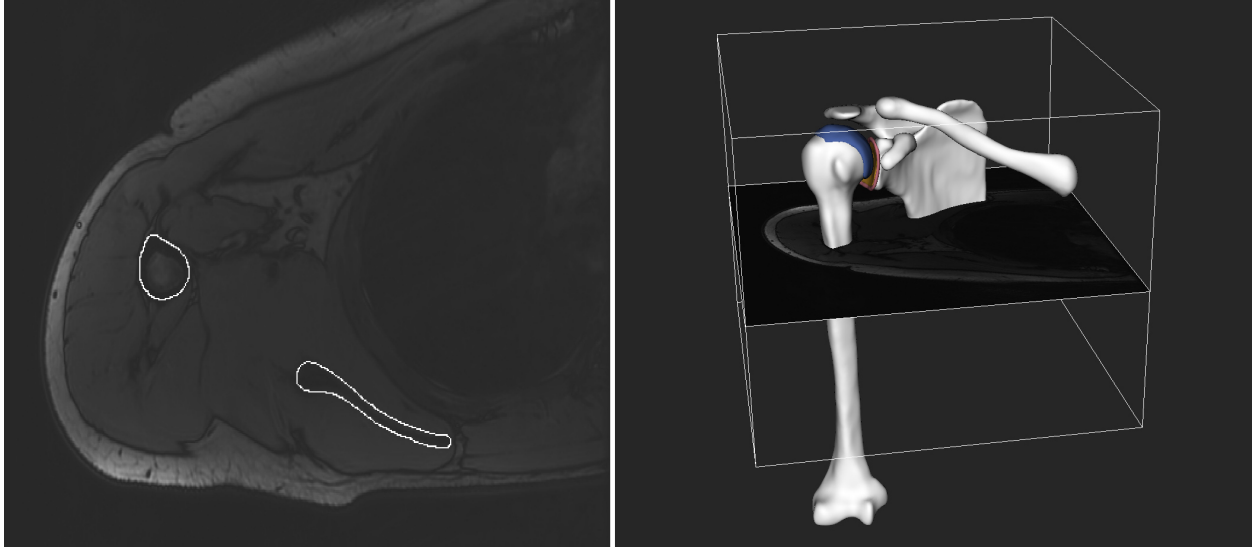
3D reconstruction of the shoulder from MRI showing the bones, labrum, glenoid and humeral cartilages.
